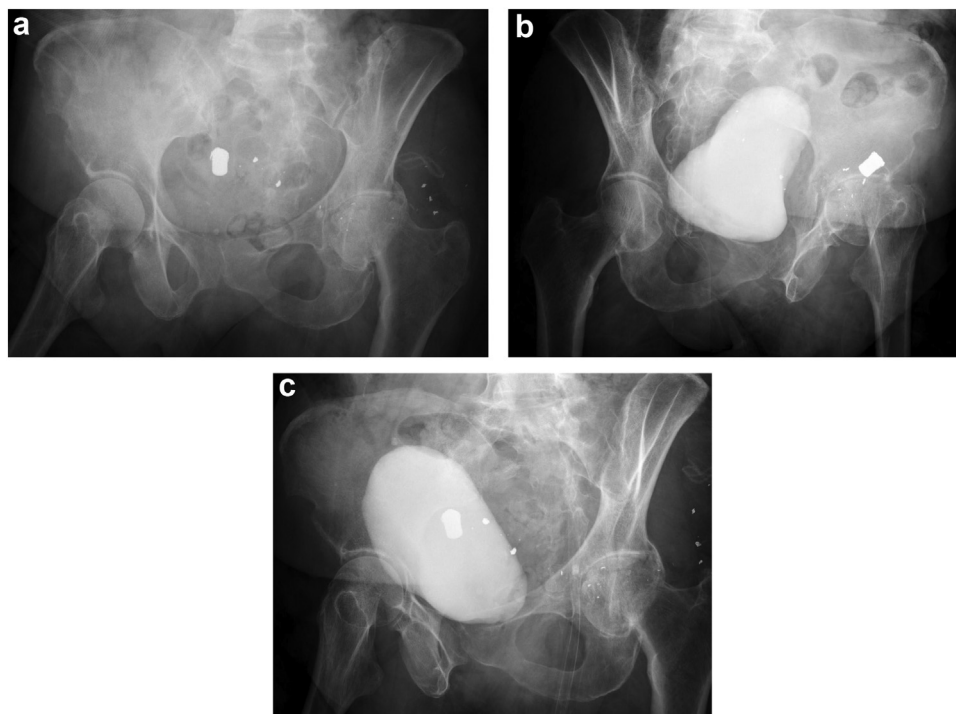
Initial radiographs include (a) anteroposterior (AP) pelvis and Judet views, (b) left iliac oblique, and (c) left obturator oblique, to characterize the resulting fracture pattern.
